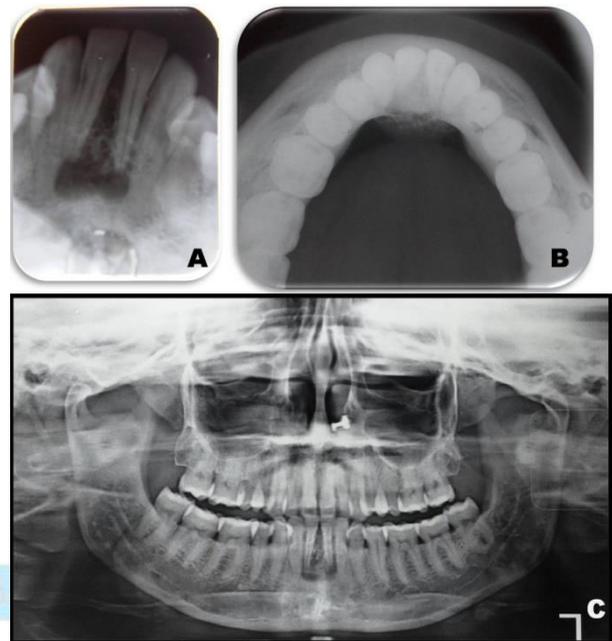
(A) Intraoral periapical radiograph i.r.t 31,32,41,42 region; (B)Mandibular cross sectional occlusal radiograph; (C) Orthopantomogram (OPG).
